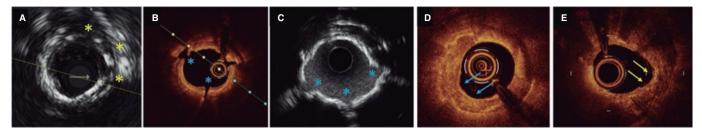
Calcium morphologies and results of different modification techniques on intravascular imaging. A: discrete calcium incisions and fracture following cutting balloon (yellow asterisk). B, C: calcium fractures following intravascular lithotripsy on optical coherence tomography and intravascular ultrasound (IVUS) (blue asterisk). Note how reverberations can be seen at fracture points (blue asterisk) on the IVUS due to acoustic waves now being able to pass through the fracture sites. D: results of calcium modification using rotational atherectomy in an uncrossable lesion. A "cored out" appearance can be seen with widening of the lumen and a semilunar appearance in some regions (blue arrow). E: results of calcium modification following orbital atherectomy. The semilunar shape of the orbital atherectomy crown can be seen at the yellow arrows.
